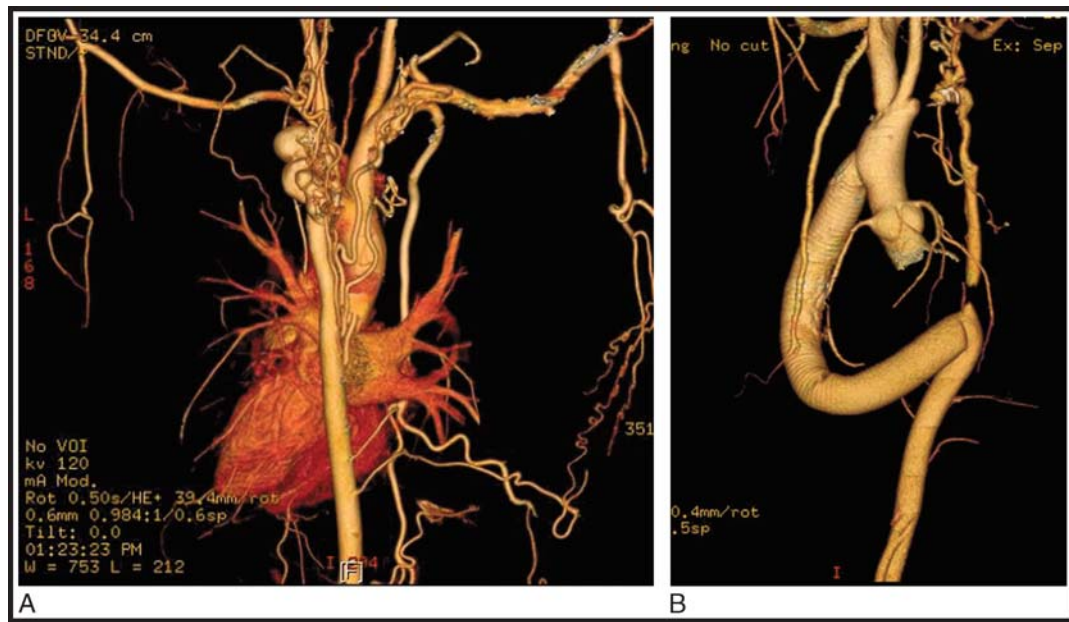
A, Computed tomographic scan taken before surgery for interruption of the aortic arch. B, Computed tomographic scan taken after the bypass procedure.
